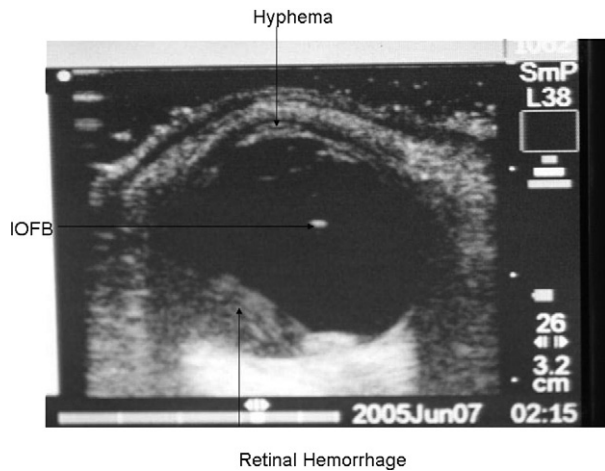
Initial ultrasound image right orbit. IOFB = intraocular foreign body.
